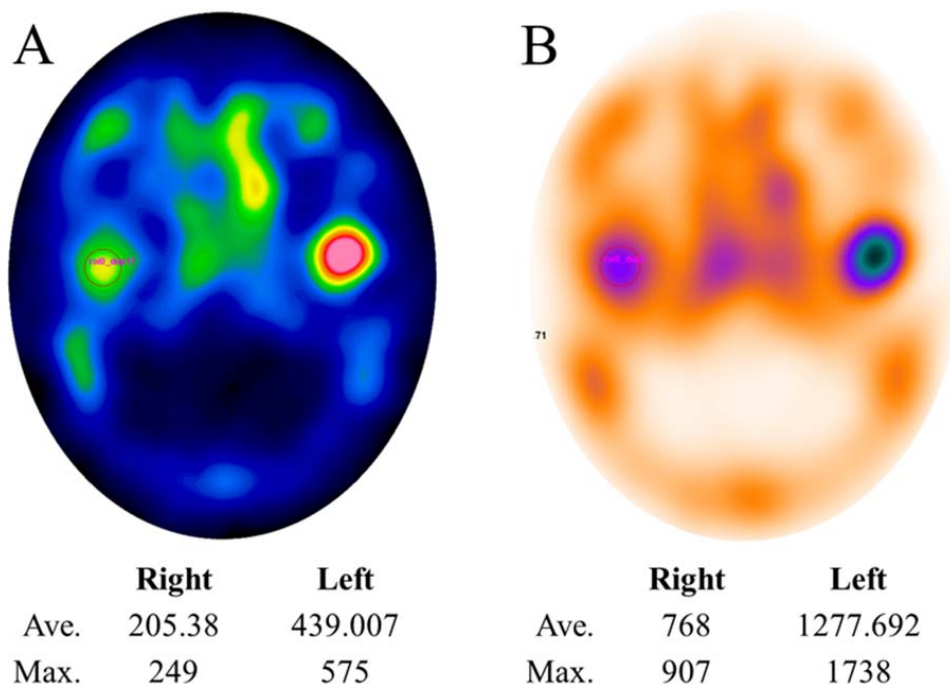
Quantitation of condylar uptake from SPECT images reconstructed without (A), i.e. SPECT alone, and with anatomical CT (B), i.e. SPECT/CT. Average and maximum counts in ROIs of identical size placed over the most intense part of the right and left condyles were measured. To be noted that counts from SPECT/CT were much greater than from SPECT which was due to attenuation correction made possible by the anatomical CT map.
